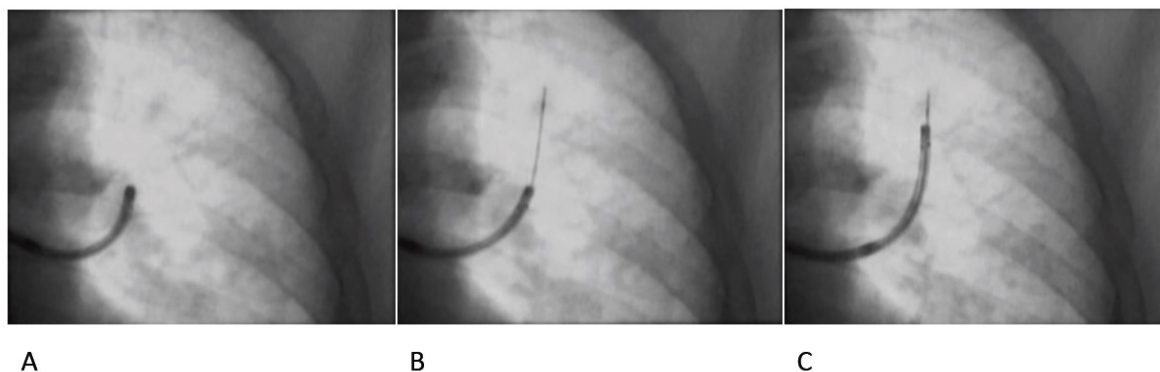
(A) The thin bronchoscope is advanced into the bronchus as far as possible, but does not reach the target lesion. (B) An ultrasonic probe is advanced toward the lesion under bronchoscopic control with fluoroscopic visualization. (C) The thin bronchoscope can be advanced further using the ultrasonic probe as a guide.
